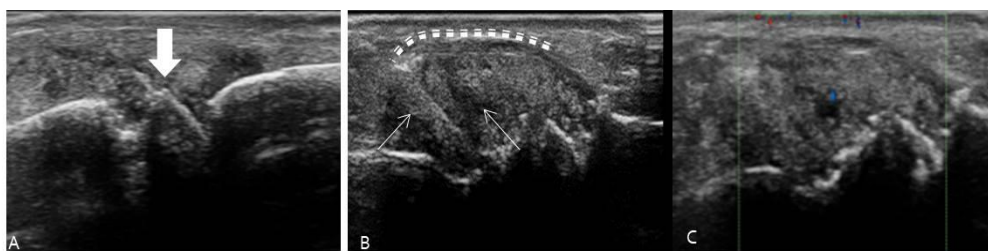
Tophaceous Gouty Arthropathy of 1st MTP A) Long axis greyscale HRUS image of medial aspect of 1st MTP, showing a sharply defined erosion (thin arrows) echogenic foci within the 1st MTP joint (block arrow) B) Long axis greyscale HRUS image on medial aspect of 1st MTP, showing distended joint capsule (dashed line) and intra-articular echogenic material with multiple dotted bright foci related to urate crystals (giving a snowstorm appearance). C) Power Doppler US image shows mild internal vascularity.
